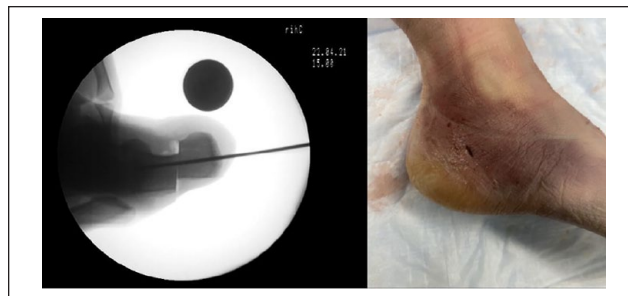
Post medial displacement osteotomy radiograph for MIS technique.
